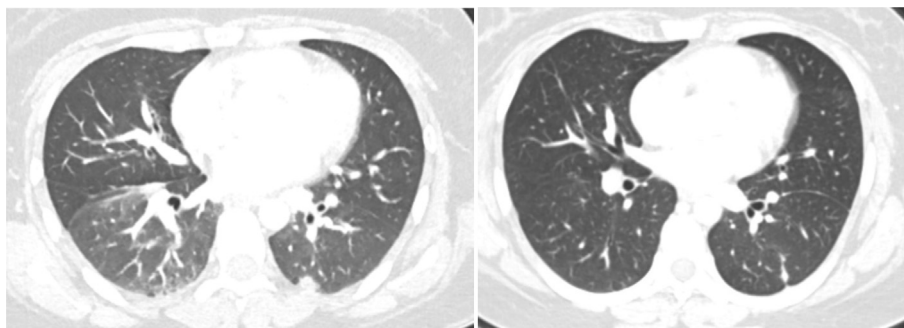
Rounded inferio-medial left lower lobe nodule present on CT on original CT scan (left); absent just prior to initiation of treatment (right).
